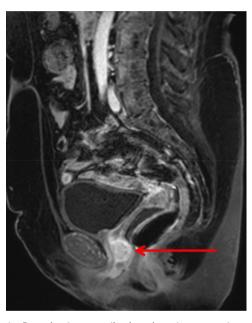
Round, circumscribed, enhancing posterior urethral mass with mass effect on the vagina on sagittal post-contrast fat-saturated MRI.
